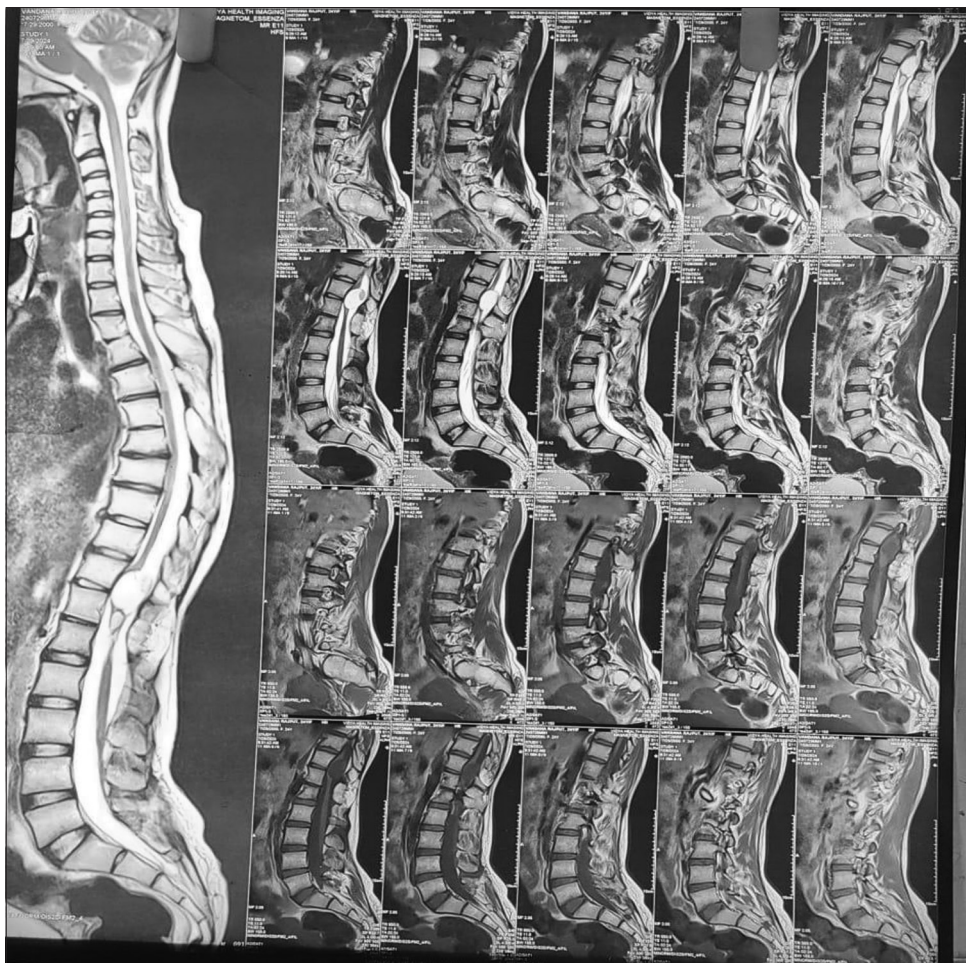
Magnetic resonance imaging of Dorso's lumbar spine with contrast sagittal view
